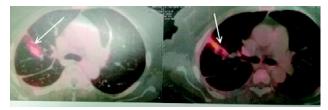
FDG-avid nodules with fibrotic strands (white arrows) in right lung upper lobe (SUV $\max = 5.4$).
